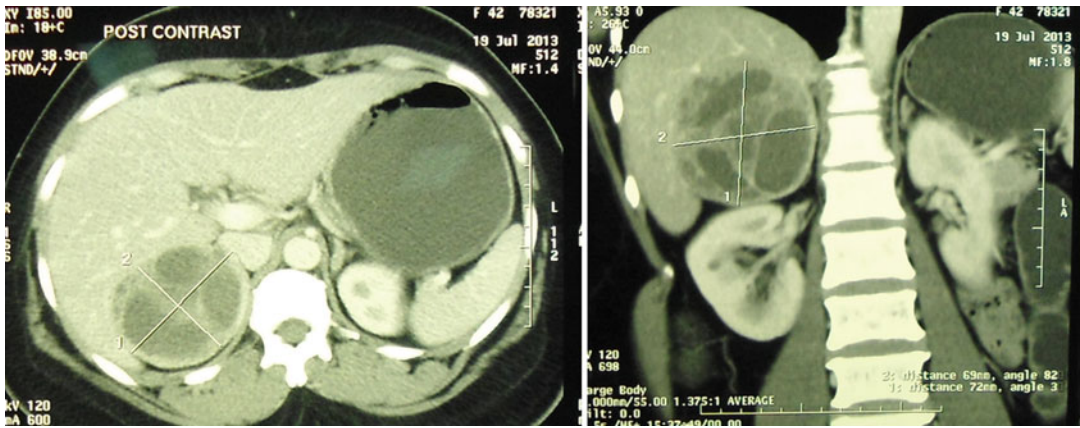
Contrast enhanced CT scan of a young female presenting with hypertension showing a large, inhomogeneous, multiloculated mass with cystic and solid areas. A mass measuring 76 × 66 × 66 mm is seen in the right adrenal gland
